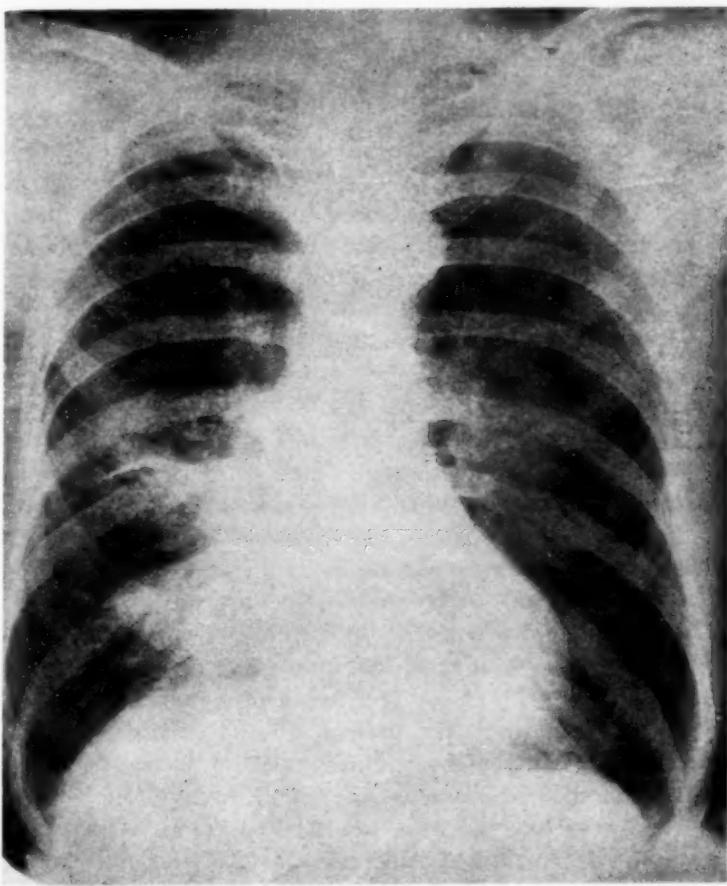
Roentgenogram of the chest of Patient 2, taken on admission to the hospital, showing an area of infiltration in the midlung zone on the right side.
